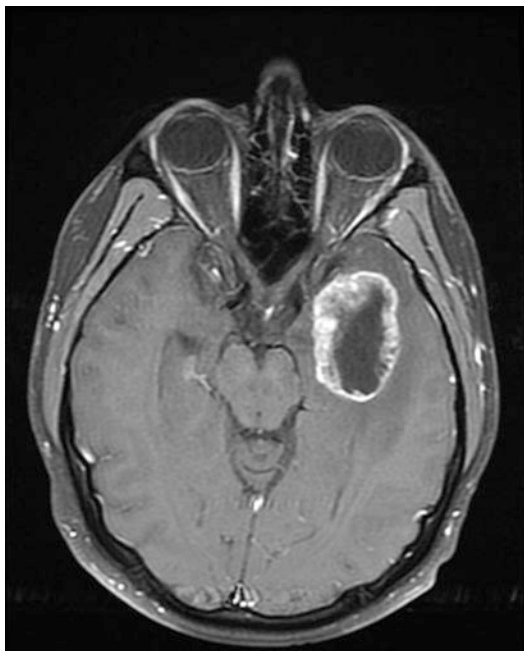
MRI scan of a metastatic brain tumor, a left temporal sarcoma
